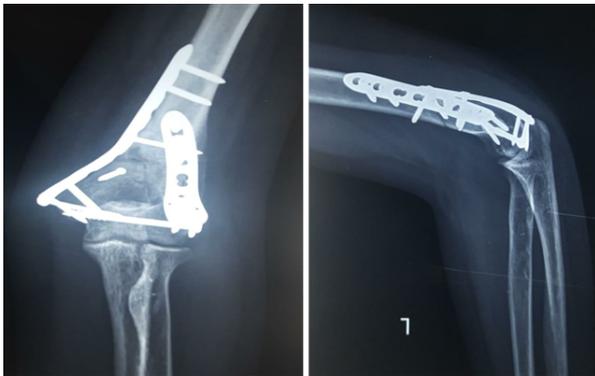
Follow-up radiograph at 3 months
